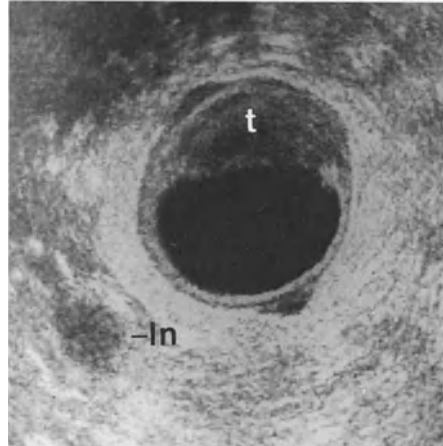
Hyperechoic lymph node (*ln*) of 5 mm diameter at the right side of the sonogram
